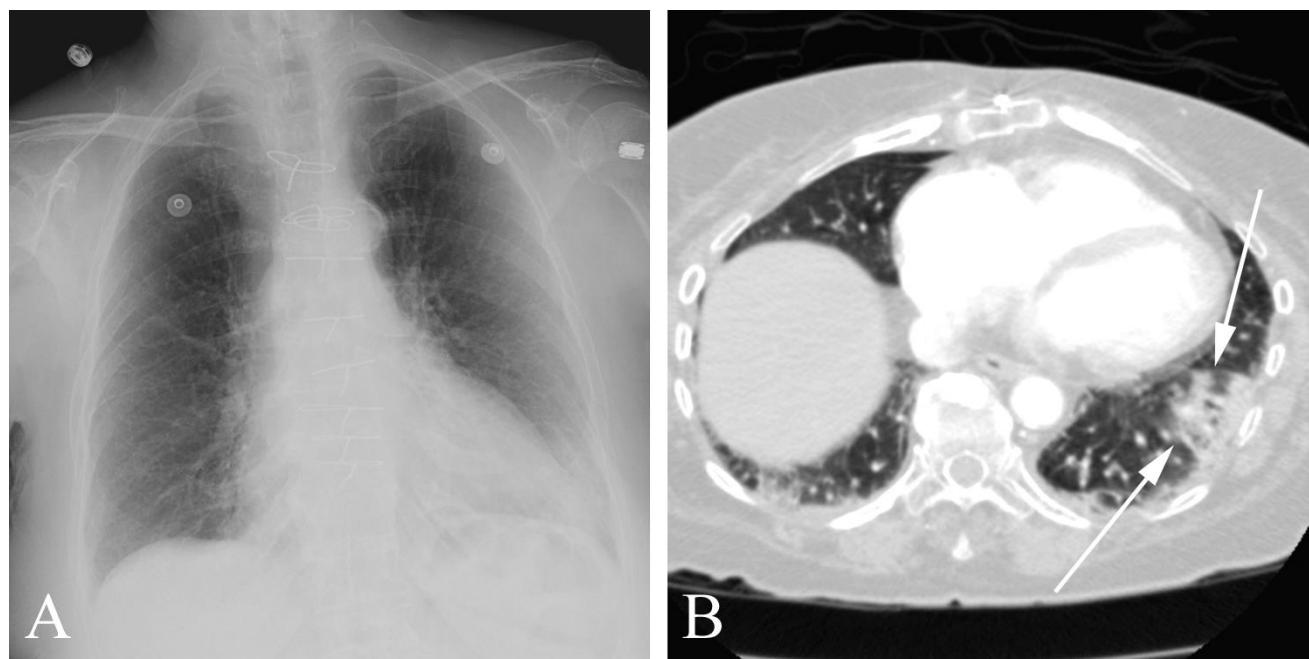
Radiographically occult pneumonia in a 78 year old woman with cough, syncope, and weakness. A. PA chest obtained at the time of the illness shows no obvious consolidation. B. Chest CT performed to exclude pulmonary embolism shows obvious opacity in the left lung base (arrows). There were no pulmonary emboli, and the patient's symptoms resolved and her elevated white blood cell count returned to normal with antibiotic treatment.
